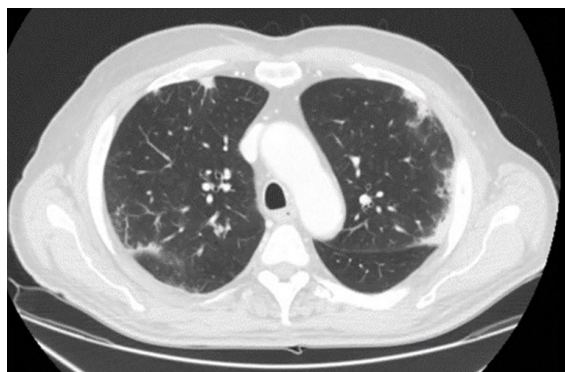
CT scan of 73-year-old man performed during treatment with cemiplimab showing diffuse and bilateral areas of ground-glass compatible with interstitial pneumonia, in the absence of symptoms. Nasopharyngeal swab excluded COVID-infection.
